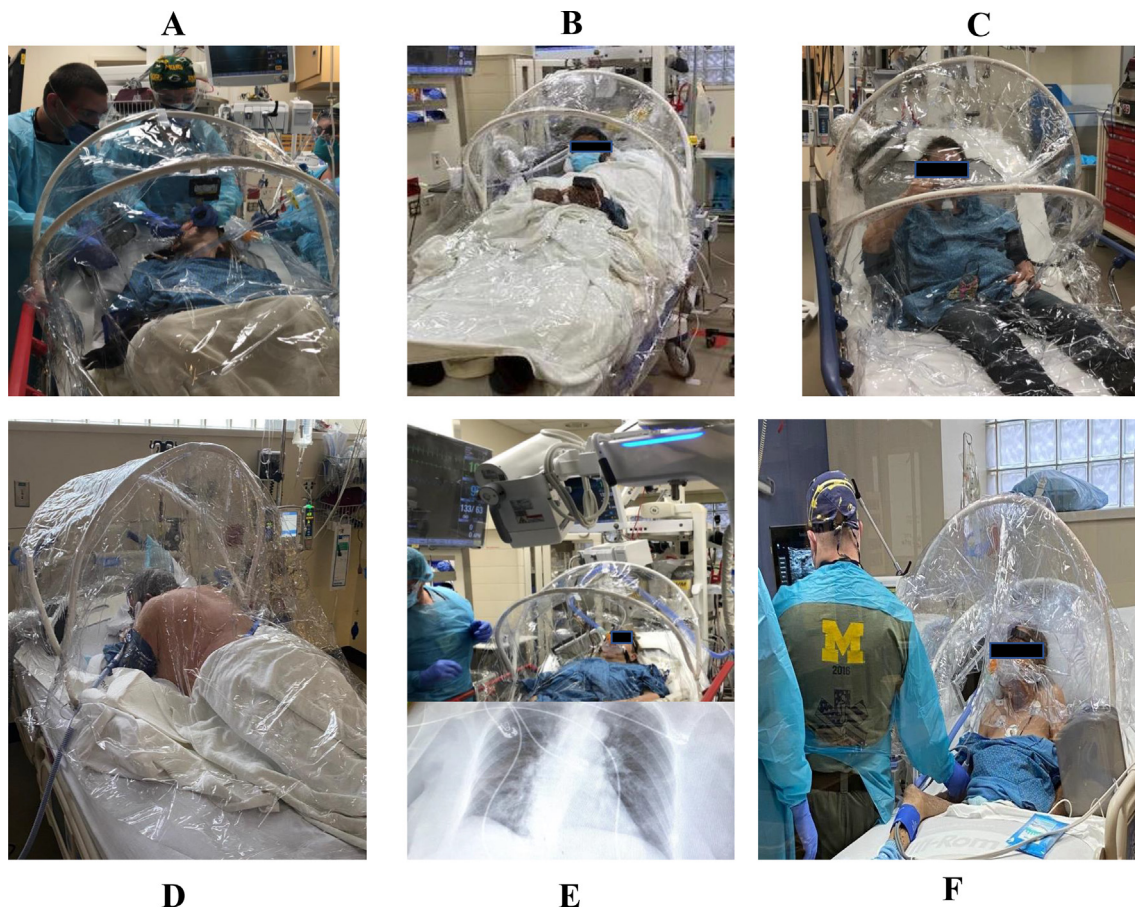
Emergency Department uses of a negative pressure procedural tent. A) endotracheal intubation; B) heated high flow nasal cannula; C) nebulized treatments; D) awake prone while on heated high flow nasal cannula; E) non-invasive ventilation and portable chest radiograph taken with tent in place; F) non-invasive ventilation and ultrasound-guided peripheral IV insertion.
